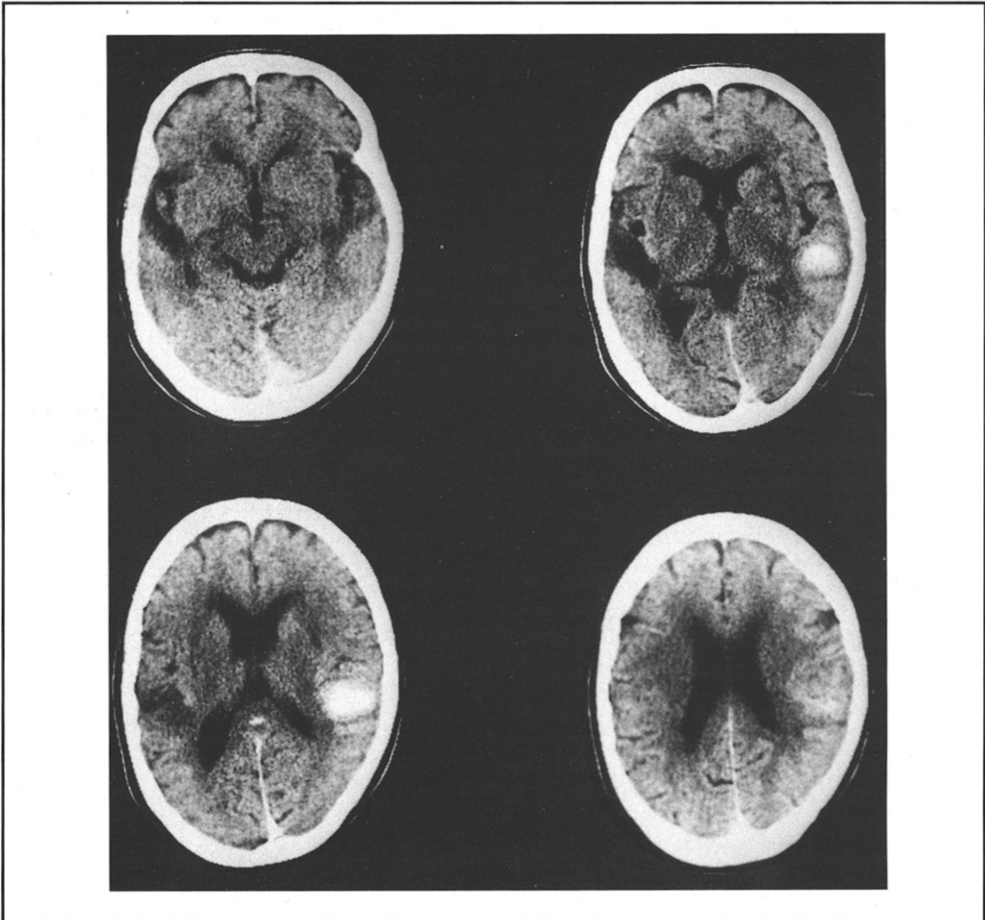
Brain CT scan one day after the onset of disease shows a high-density area in the posterior quarter of the right temporal lobe.
